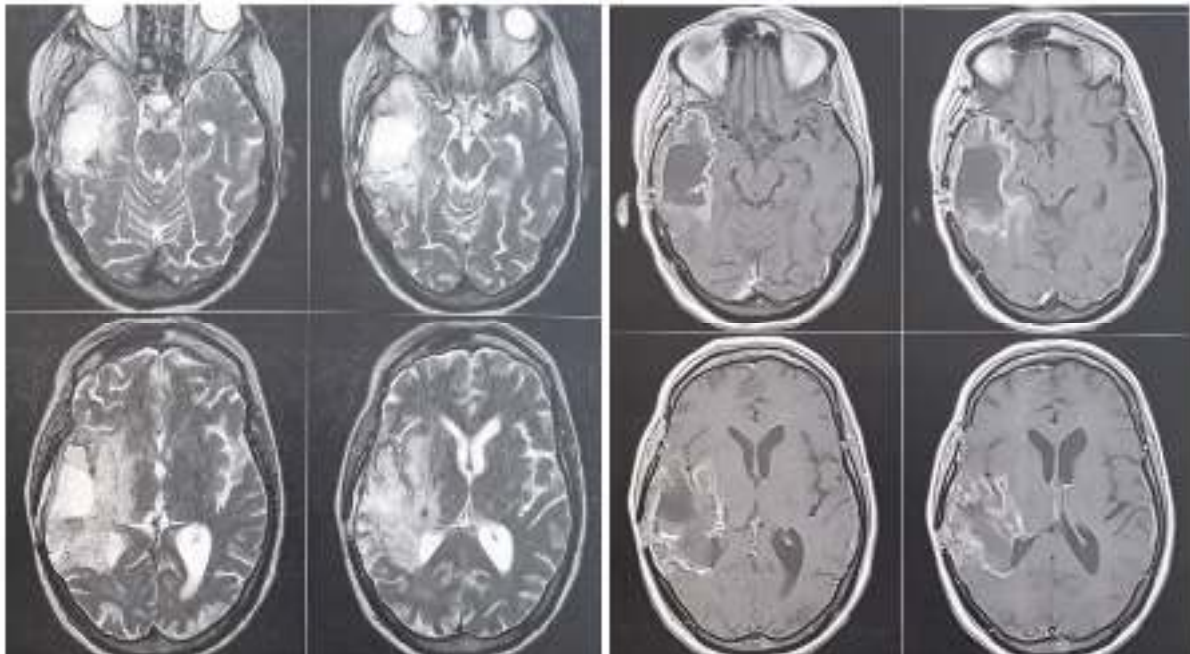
control MRI after 10 months of the 49 years old patient diagnosed with temporal lobe glioblastoma.
